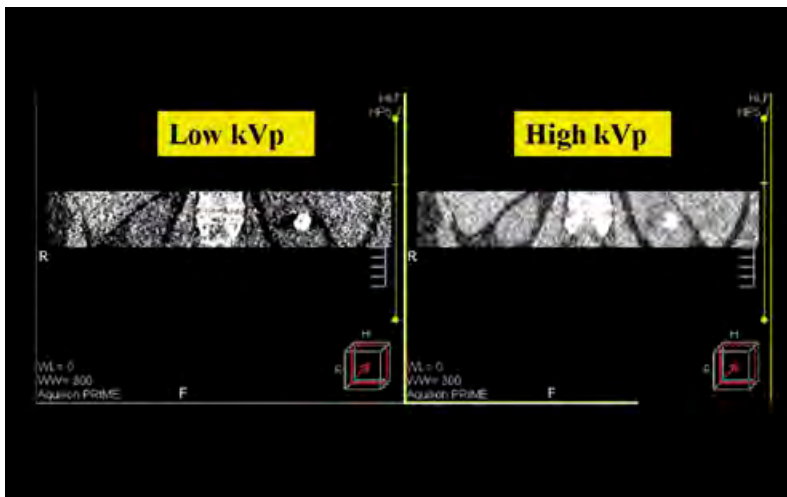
Coronal CT images of the kidneys at low kV, high mA (left), high kV, low mA (right)
